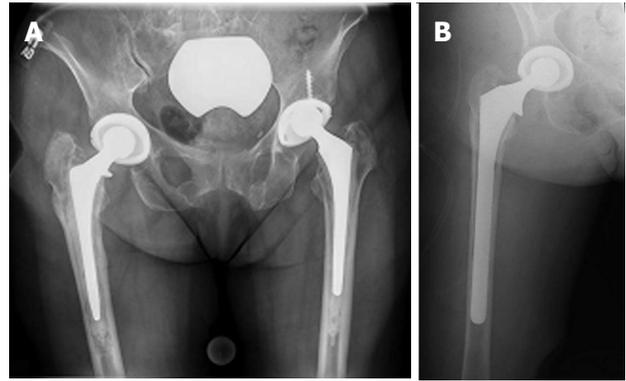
Extensively porous coated stems. A: Anteroposterior (AP) radiograph of the pelvis demonstrating bilateral total hip arthroplasties. In right hip there is evident loosening of the femoral stem and extensive metaphyseal cancellous bone loss with some diaphyseal bone loss, which is limited to less than 4 cm of diaphyseal bone; B: AP radiograph of the same hip post revision using an extensively porous coated stem.
